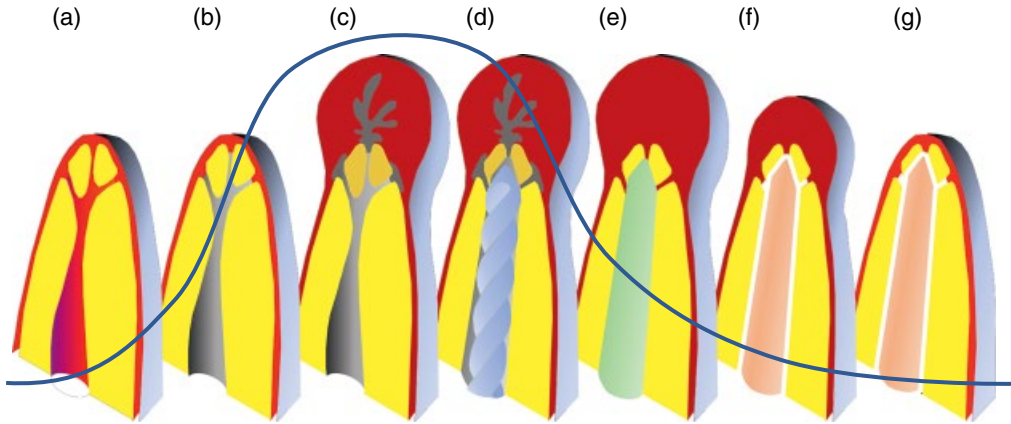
Development and healing of apical periodontitis related to the level of infection. Microbes in the root canal system (a, b) initiates and sustains the periapical inflammation (c); mechanical instrumentation (d), irrigation and medication (e), and root filling (f) reduce the level of infection sufficiently for repair and regeneration of the apical periodontal structures (g) [148].
